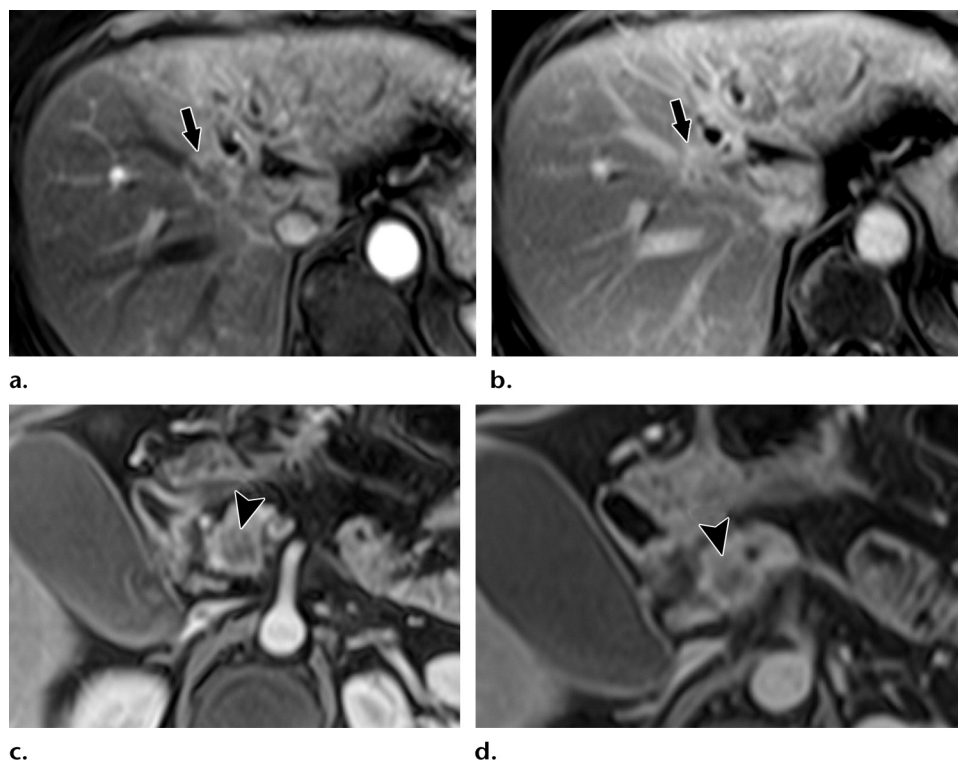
Imaging similarities between extrahepatic cholangiocarcinoma (a, b) and pancreatic ductal adenocarcinoma (c, d). (a, b) Axial gadolinium-enhanced T1-weighted MR images of a 58-year-old man obtained during the arterial phase (a) and the portal venous phase (b) show an ill-defined mass (arrow) at the hepatic hilum, with heterogeneous peripheral enhancement during the arterial phase and progressive enhancement during the portal venous phase. (c, d) Axial gadolinium-enhanced T1-weighted MR images of an 82-year-old man obtained during the arterial phase (c) and the portal venous phase (d) show a mass (arrowhead) in the pancreatic head, with progressive contrast enhancement. The considerable amount of fibrotic tissue within both malignancies is likely the cause of the similarity in the imaging findings.
